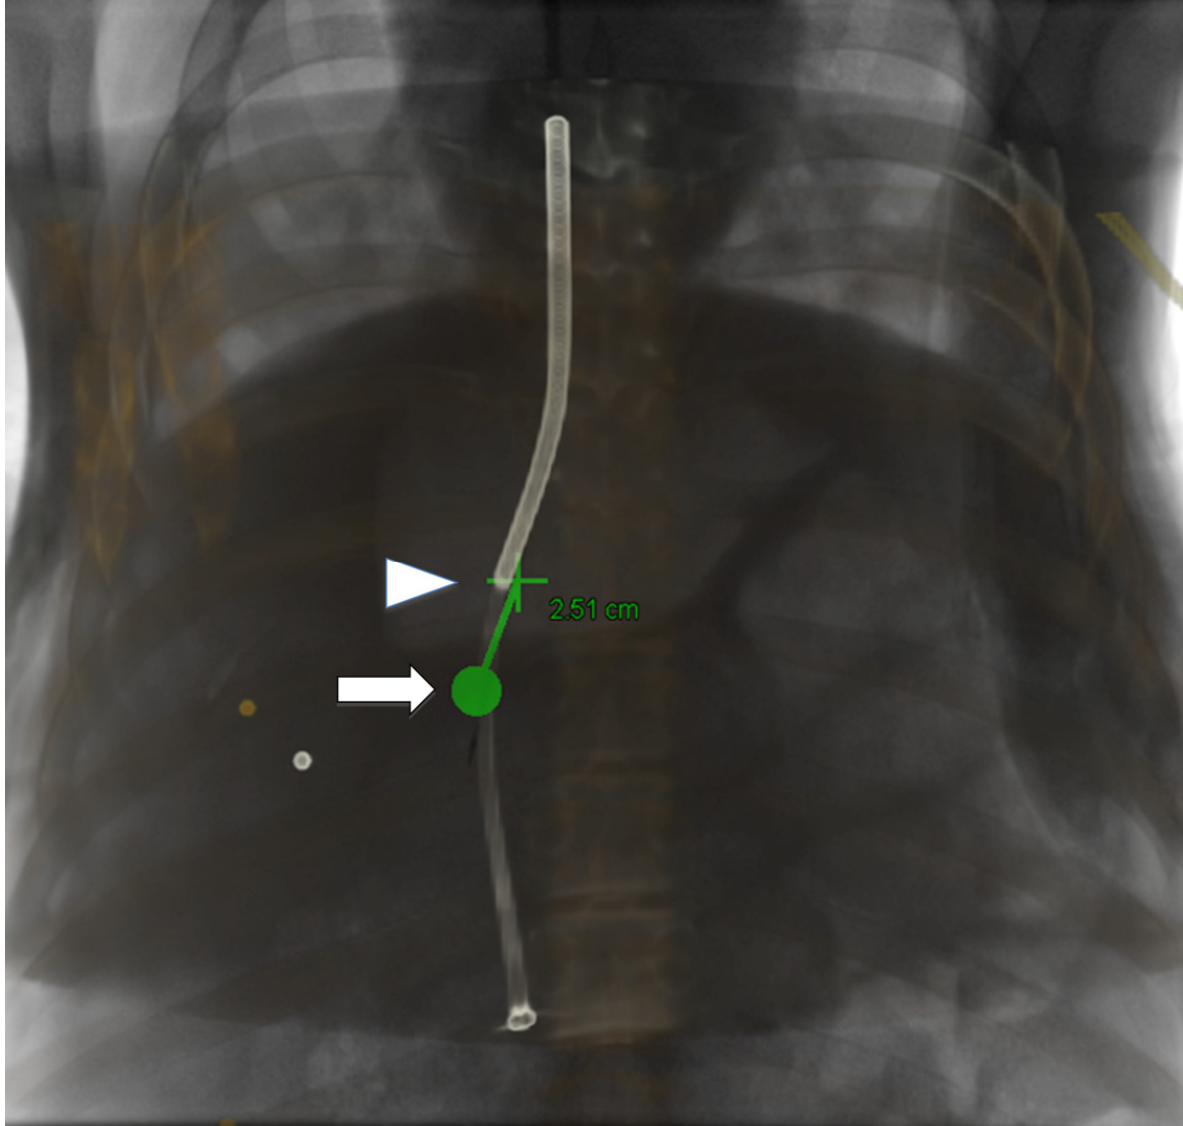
CBCT-guided TIPS: (A) procedure for the creation of a fusion image of CBCT, with the green dot (which was derived from CBCT reconstruction images) showing where the target (portal vein) was; (B) a fluoroscopic image of the pre-portal vein puncture for the 3DFIG TIPS procedure, demonstrating the virtual path (green) of the portal vein puncture, the location of the needle tip in the hepatic vein (black arrow) with the expected puncture distance and the expected location of the portal vein (white arrow).
